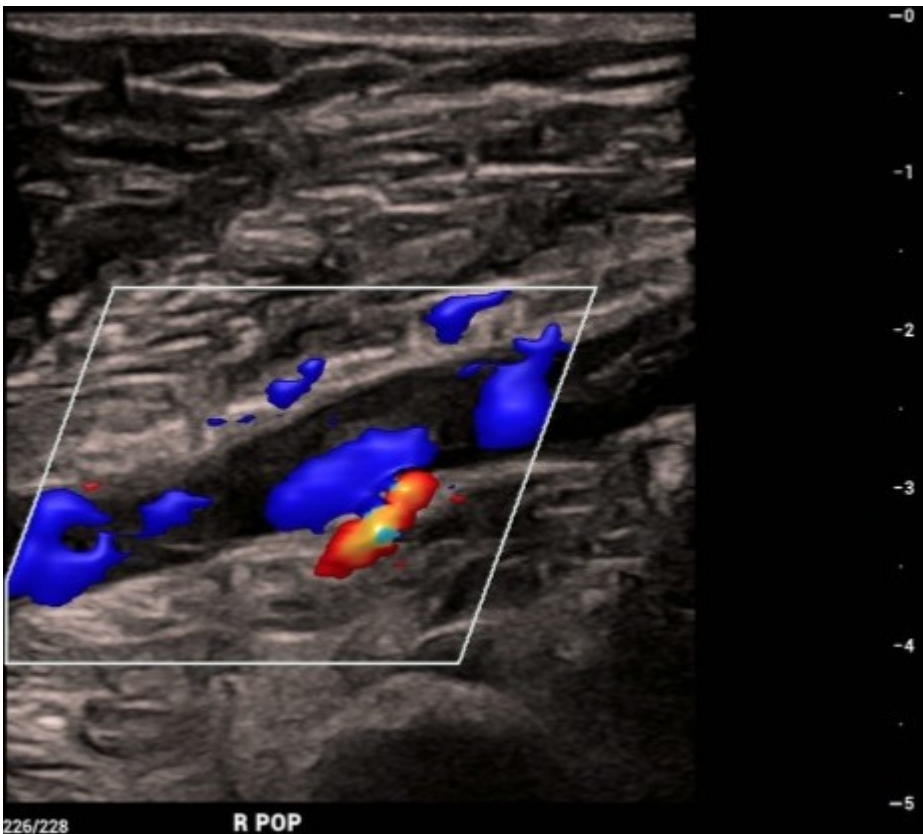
Long axis color doppler ultrasound image of the popliteal vein with echogenic filling defect in the lumen with incomplete occlusion with areas of flow through the vein. Of note, the distal vein (right side of the image) is larger than the proximal vein (left side of the image).
